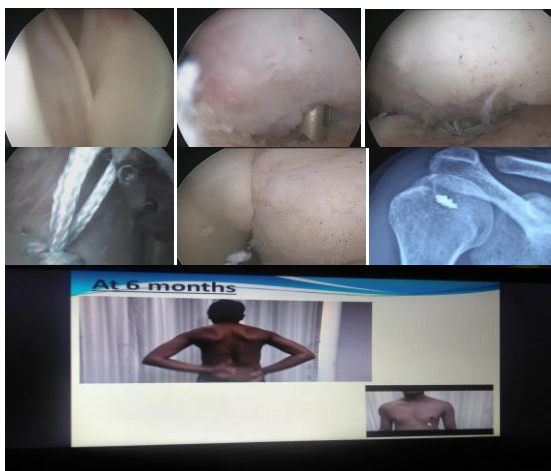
Operative and post operative X-ray-Hill Sachs lesion and remplissage procedure done arthroscopically.
